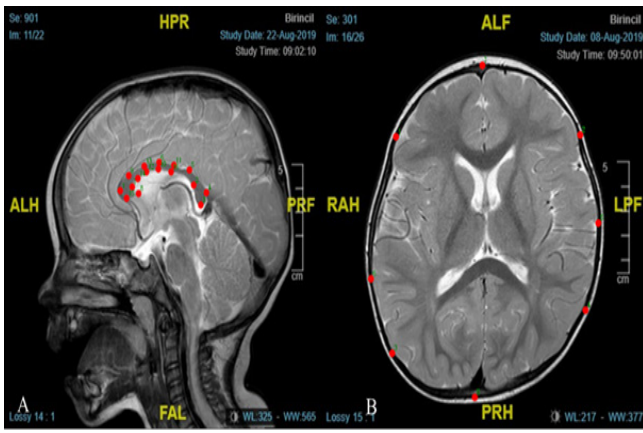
A) T1-weighted mid-sagittal slice demonstrating the corpus callosum landmarks; B) Landmark markings on the cranium.
